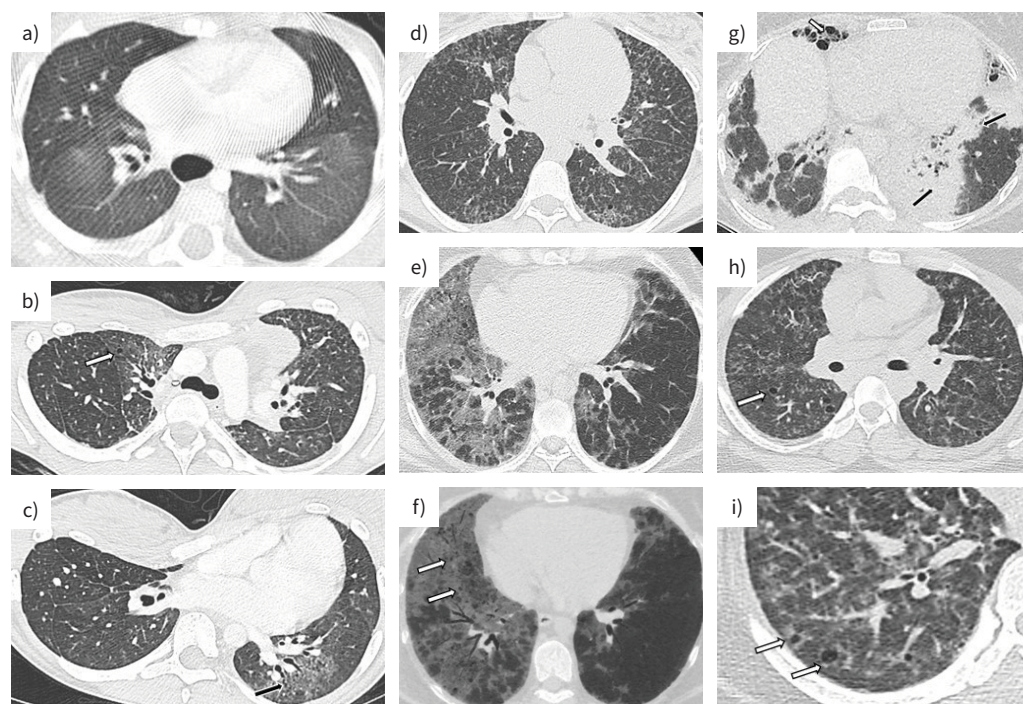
Computed tomography (CT) patterns associated with surfactant-related gene (SRG) mutation. a) Interstitial lung disease (ILD) revealed at the age of 8 months in 2003, in a *SFTPC* mutation carrier infant, showing diffuse ground-glass opacities. b) At the age of 14 years, the patient received prednisone and the chest CT performed in 2018 (b and c) shows less extensive ground-glass opacities, but mild traction bronchiectasis (black arrow), mild subpleural reticular opacities and small cysts (white arrow) have appeared. A severe thoracic deformation (pectum excavatum and scoliosis) has developed. d) 32-year-old smoking woman with an *SFTPA1* mutation presenting with predominantly ground-glass ILD, accompanied by reticular and small nodular opacities, which remained stable for several years following smoking cessation. e) 30-year-old nonsmoking woman with mostly ground-glass opacities associated with a compound heterozygous *ABCA3* mutation and associating small cysts (f white arrows), best depicted using minimum intensity projection reconstruction. g) 47-year-old smoking woman with known fibrosing ILD (honeycombing, white arrow) associated with *NKX2-1* mutation and newly appeared consolidations (black arrows) that were eventually related to lung cancer. h and i) 14-year-old girl with *SFTPC* mutation with ground glass and reticular opacities and associated small cysts (white arrows).
